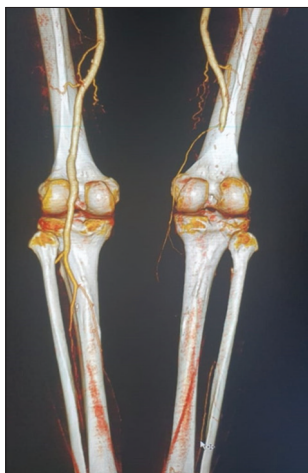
Multislice computed tomography angiography which represent thromboembolism of right popliteal and crural arteries
